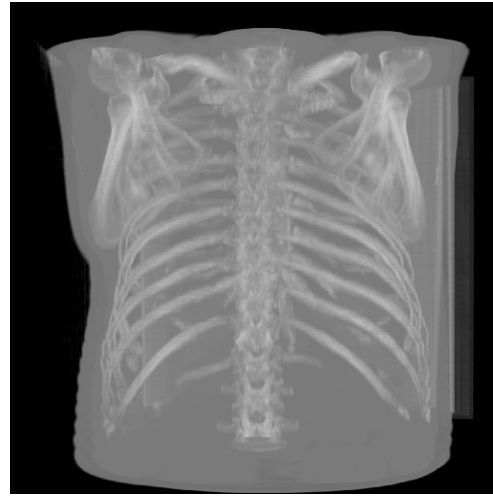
DRR image (a) MIP image (b) X-ray image*
